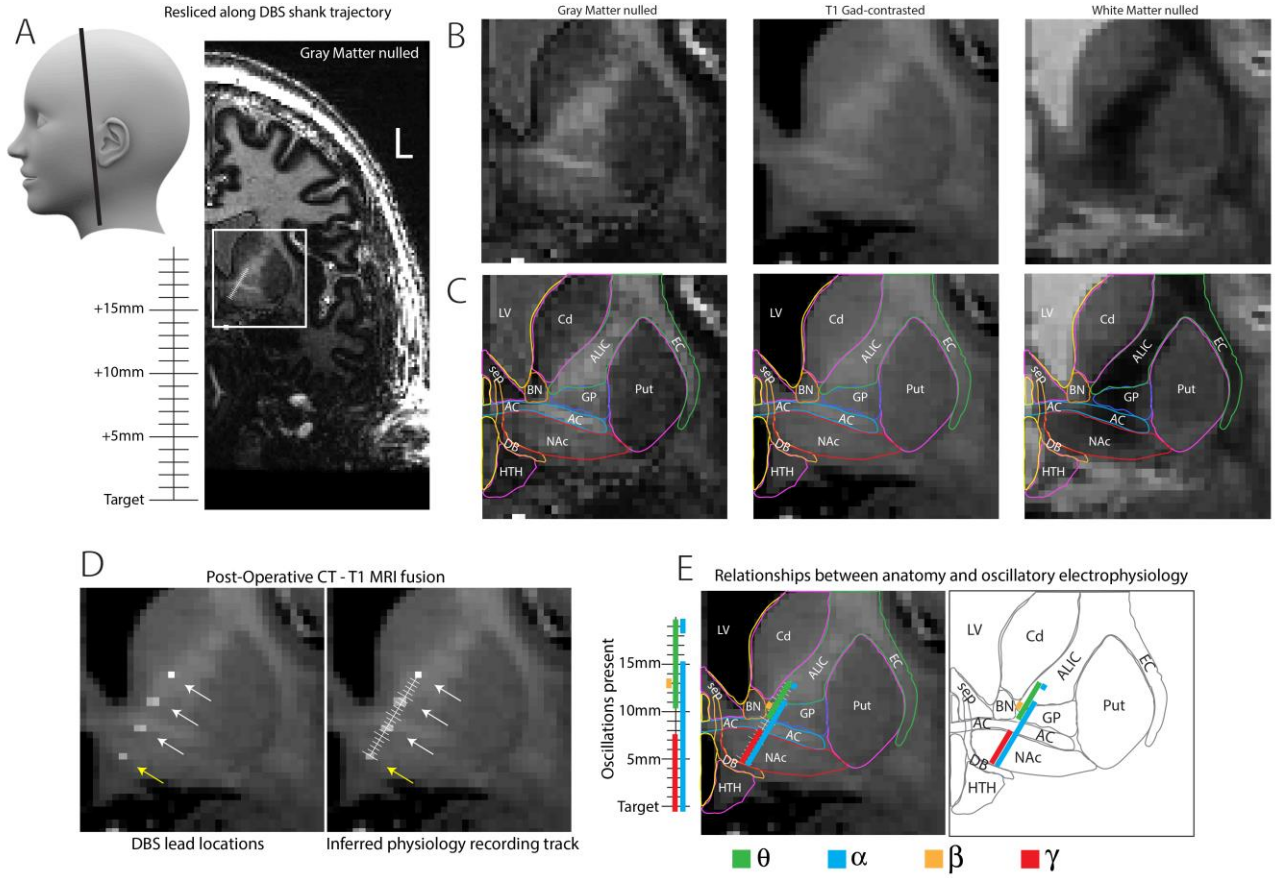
In-plane reslicing along the DBS lead with multiple ride-along MR images enabled anatomic localization of the microelectrode recordings. During this DBS implantation surgery to treat obsessive compulsive disorder, microelectrode recordings were made in 1 mm intervals approaching the nucleus accumbens (figure adapted from online methodology for [5], used with permission). The DBS reslicing tool was used to produce this figure and assign the microelectrode recordings to their anatomic location. (A) A pseudo-coronal slice in the plane of the DBS lead and microelectrode recordings is shown with a scale bar. (B) Gray matter nulled, T1 Gad-contrast, and white matter nulled images were simultaneously resliced using the ride along feature. (C) All three types of MR images were necessary to segment nucleus accumbens and the nearby structures. (D) The fused post-operative CT and pre-op T1 show the location of the DBS electrode sites, allowing the recording track to be inferred. (E) When combined with electrophysiology analysis, the electrophysiological properties specific to nucleus accumbens were found.
